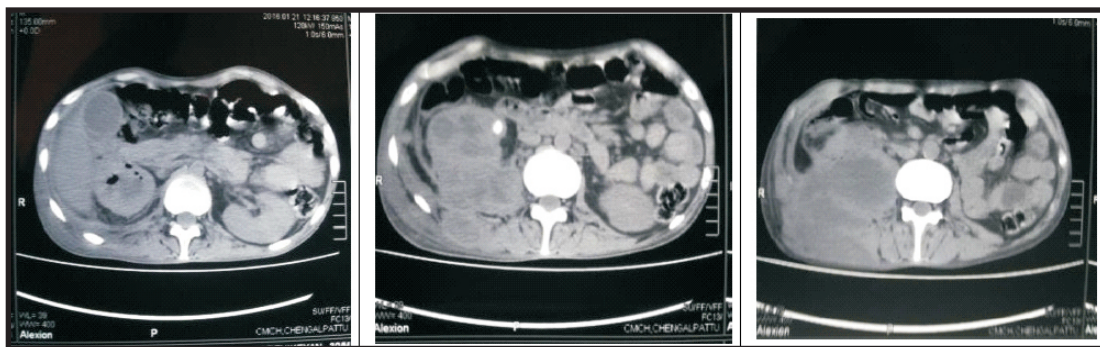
CT scan of the abdomen and pelvis taken 1 month later showing gas bubbles in the renal parenchyma characteristics of Emphysematous pyelonephritis and last image showing perirenal abscess extending posteriorly.
